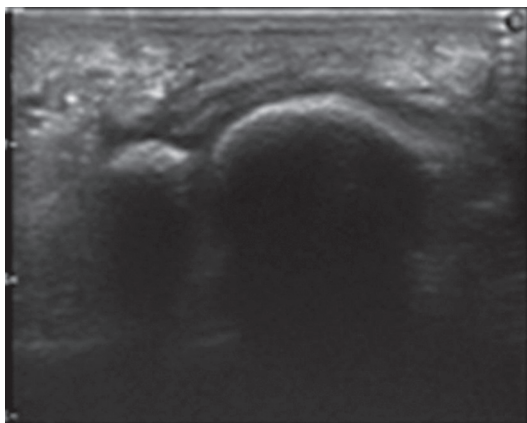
Sonographic scan showing plantar plate tear graded G2 with the Hamilton-Thompson test
